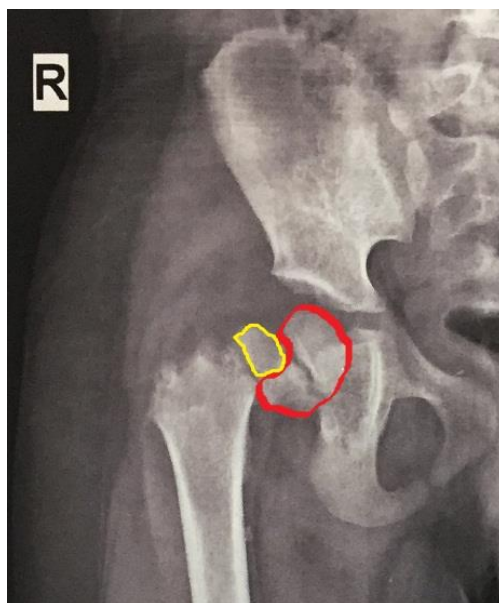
Radiograph focused on the fracture (red circle around the metaphysis and epiphysis)
